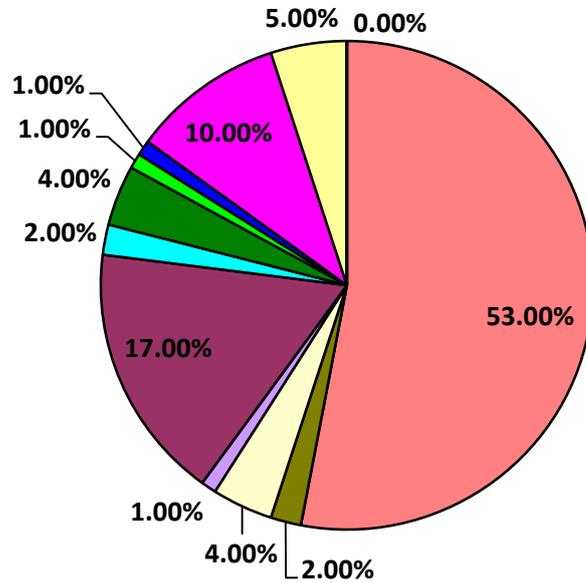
Ultrasonographical diagnosis
